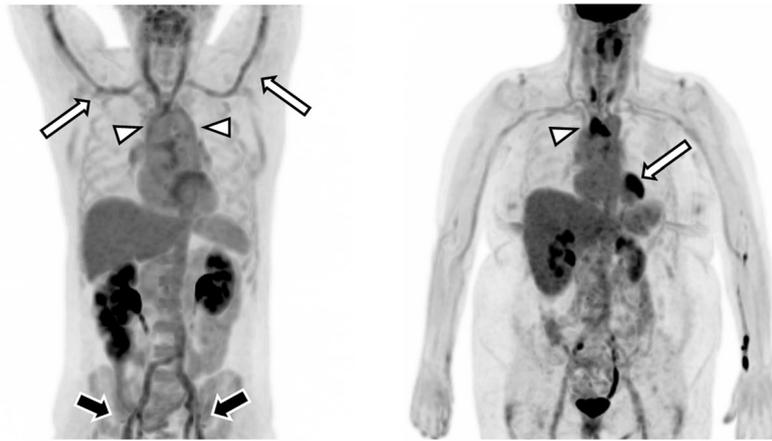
Left: maximal intensity projection (MIP) image of a FDG PET/CT scan of a 54-year-old male with giant cell arteritis. There is increased uptake along the ascending aorta, aortic arch (arrow heads), subclavian arteries (white arrows), and carotid arteries. The intensity of the uptake is greater than liver activity (grade 3), compatible with vasculitis. There is also grade 3 uptake in the iliofemoral arteries, compatible with vasculitis (black arrows). Right: maximal intensity projection (MIP) image of a FDG PET/CT scan of a 58-year-old female who initially presented with an anterior ST elevation myocardial infarction (STEMI). Angiography
